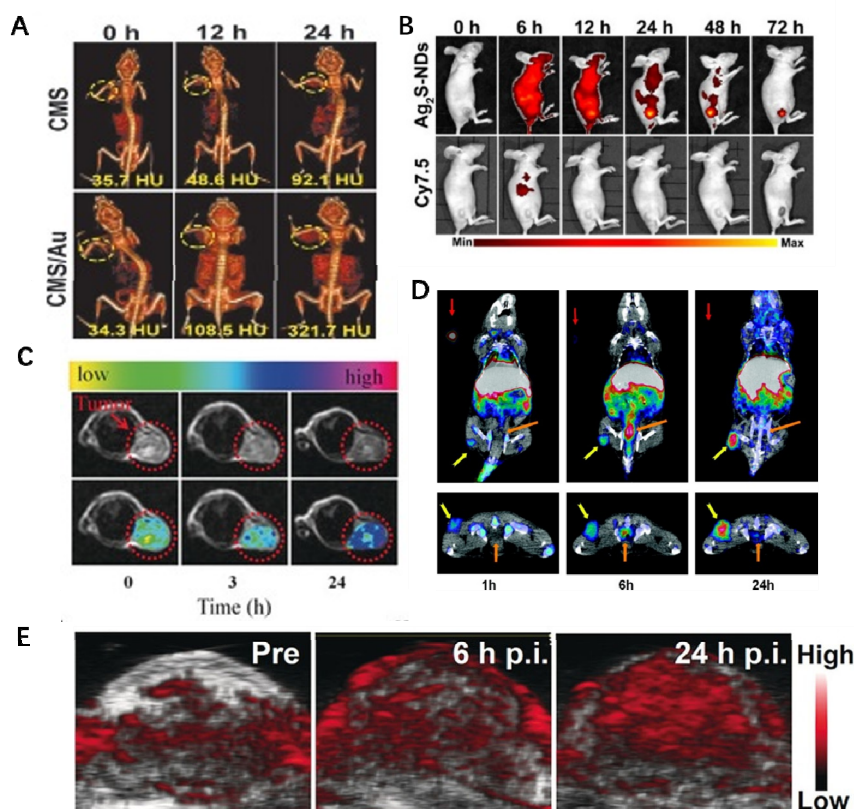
A. The CT signal intensity of Cu_2MoS_4 (CMS) and CMS/Au solutions with different concentrations showed a linear relationship with the material concentration.⁷⁰ Copyright 2020. B. Ag_2S nanodots for Second Near-Infrared FI.¹⁰ Copyright 2017. C. Fe_2P for MRI.³⁰ Copyright 2019. D. PEG- $[^{64}Cu]$ CuS for Micro-PET/CT images.⁷¹ Copyright 2010. E. VS_2 nanodots for PAI.⁷² Copyright, 2017. Reproduced/Adapted with permission.
